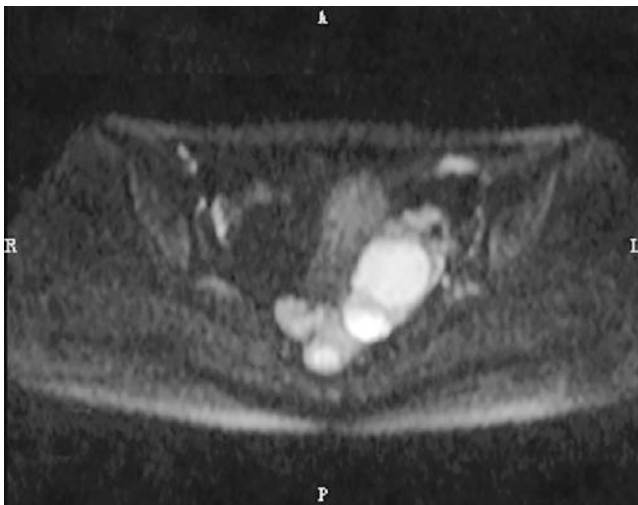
High-bright signal was shown on DWI, and that is T2-shine through effect
